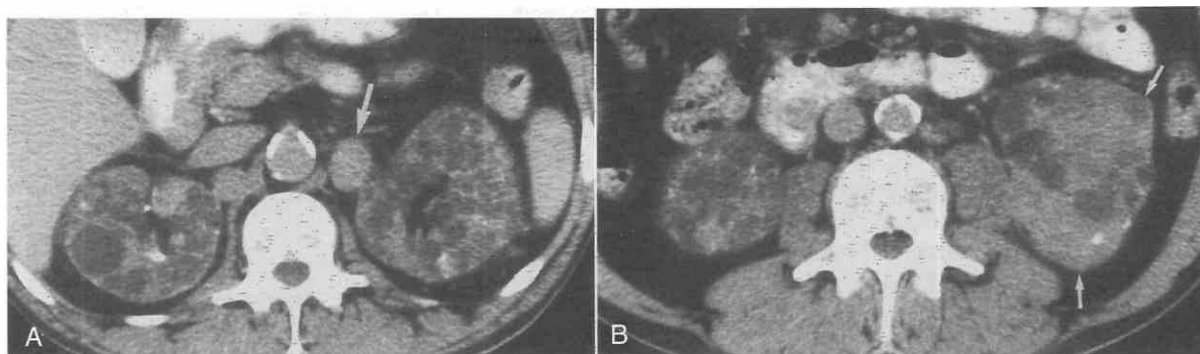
Acquired renal cystic disease and metastatic renal cell carcinoma in a 46-year-old man treated with hemodialysis for 120 months. *A*, Contrast-enhanced CT scan shows multiple bilateral renal cysts and nephromegaly. The enlarged left renal hilar lymph node (*arrow*) is due to a metastasis. *B*, A caudal CT scan reveals two solid, heterogeneous masses (*arrows*) with irregular contours and focal calcifications in the lower pole of the left kidney. The masses enhanced by 30 HU. (From Levine E, Slusher SL, Grantham JJ, Wetzel LH: Natural history of acquired renal cystic disease in dialysis patients: A prospective longitudinal CT study. *AJR Am J Roentgenol* 156:501–506, 1991.)
